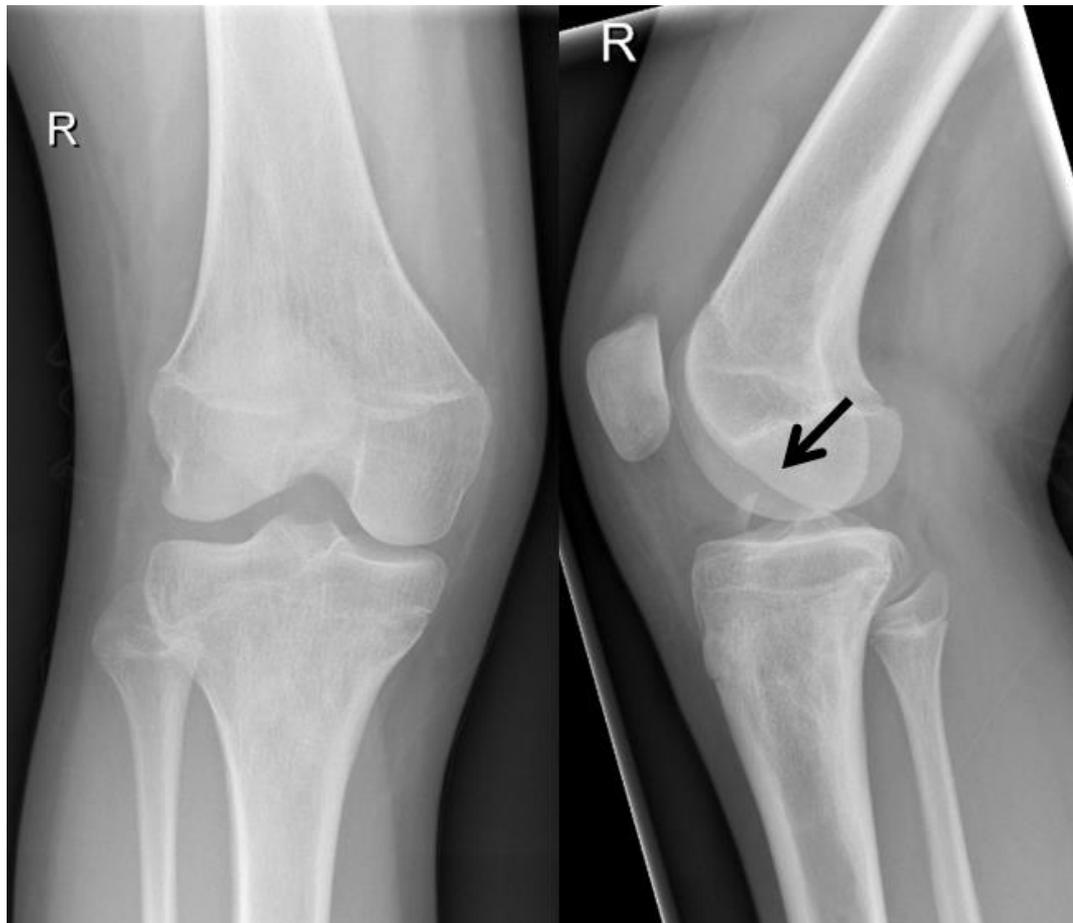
Primary radiographs showed a loose bone fragment in the knee joint
